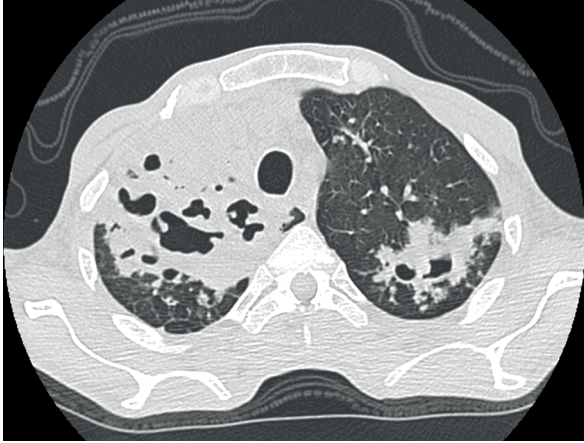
CT images of a 45-year old man with severe Covid-19 infection (day 15) and respiratory failure hospitalized at ICU. Multiple, big lung cavities mainly in the right upper lobe with diffuse big consolidations, patchy consolidations, peripheral GGOs with air bubble signs in the lower lobes. Reticular pattern can also be seen. Note no pleural effusion.
